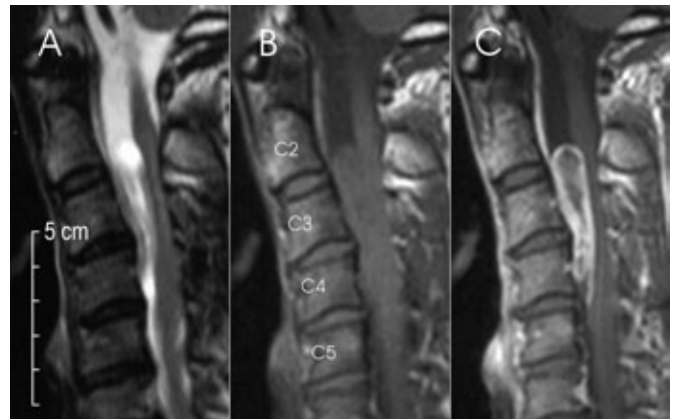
Sagittal magnetic resonance images from C2-C6 prior to surgery. (A) T2 weighted images showed an intradural extramedullary tumor with cystic components located behind the C2/3 disc and extending to behind the C4 vertebral body. (B) T1 sequences showed the tumor to be isointense with the spinal cord. (C) Contrast enhancement was present throughout the tumor but especially around the capsule.
